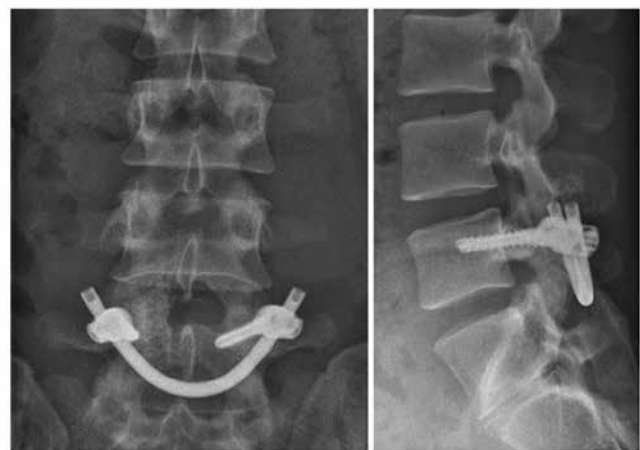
Plain radiographs after the surgery show correct placement of the two pedicle screws and the entire lamina secured with the U-shaped rod.
